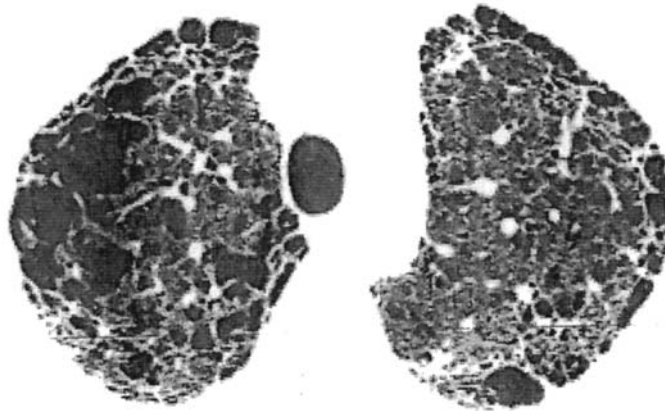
UIP. HRCT (upper lobes) showing extensive peripheral honeycomb change. No significant GGO.
